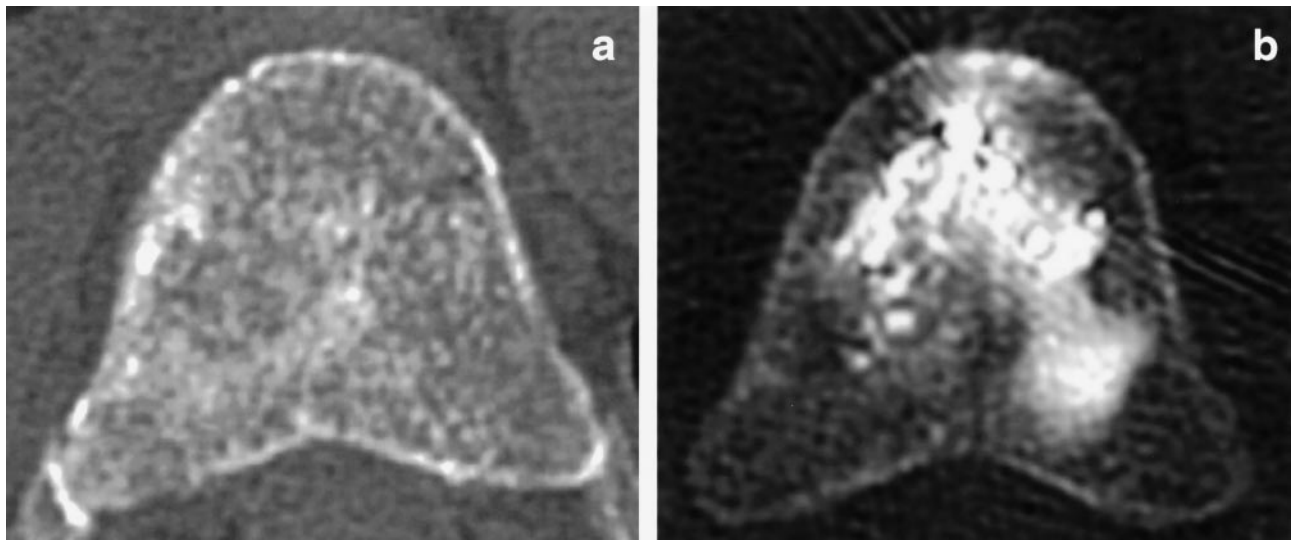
(a) Pretreatment CT of D6 vertebral body. (b) Posttreatment CT of D6 vertebral body. Note extension of radiopaque PMMA implant.
